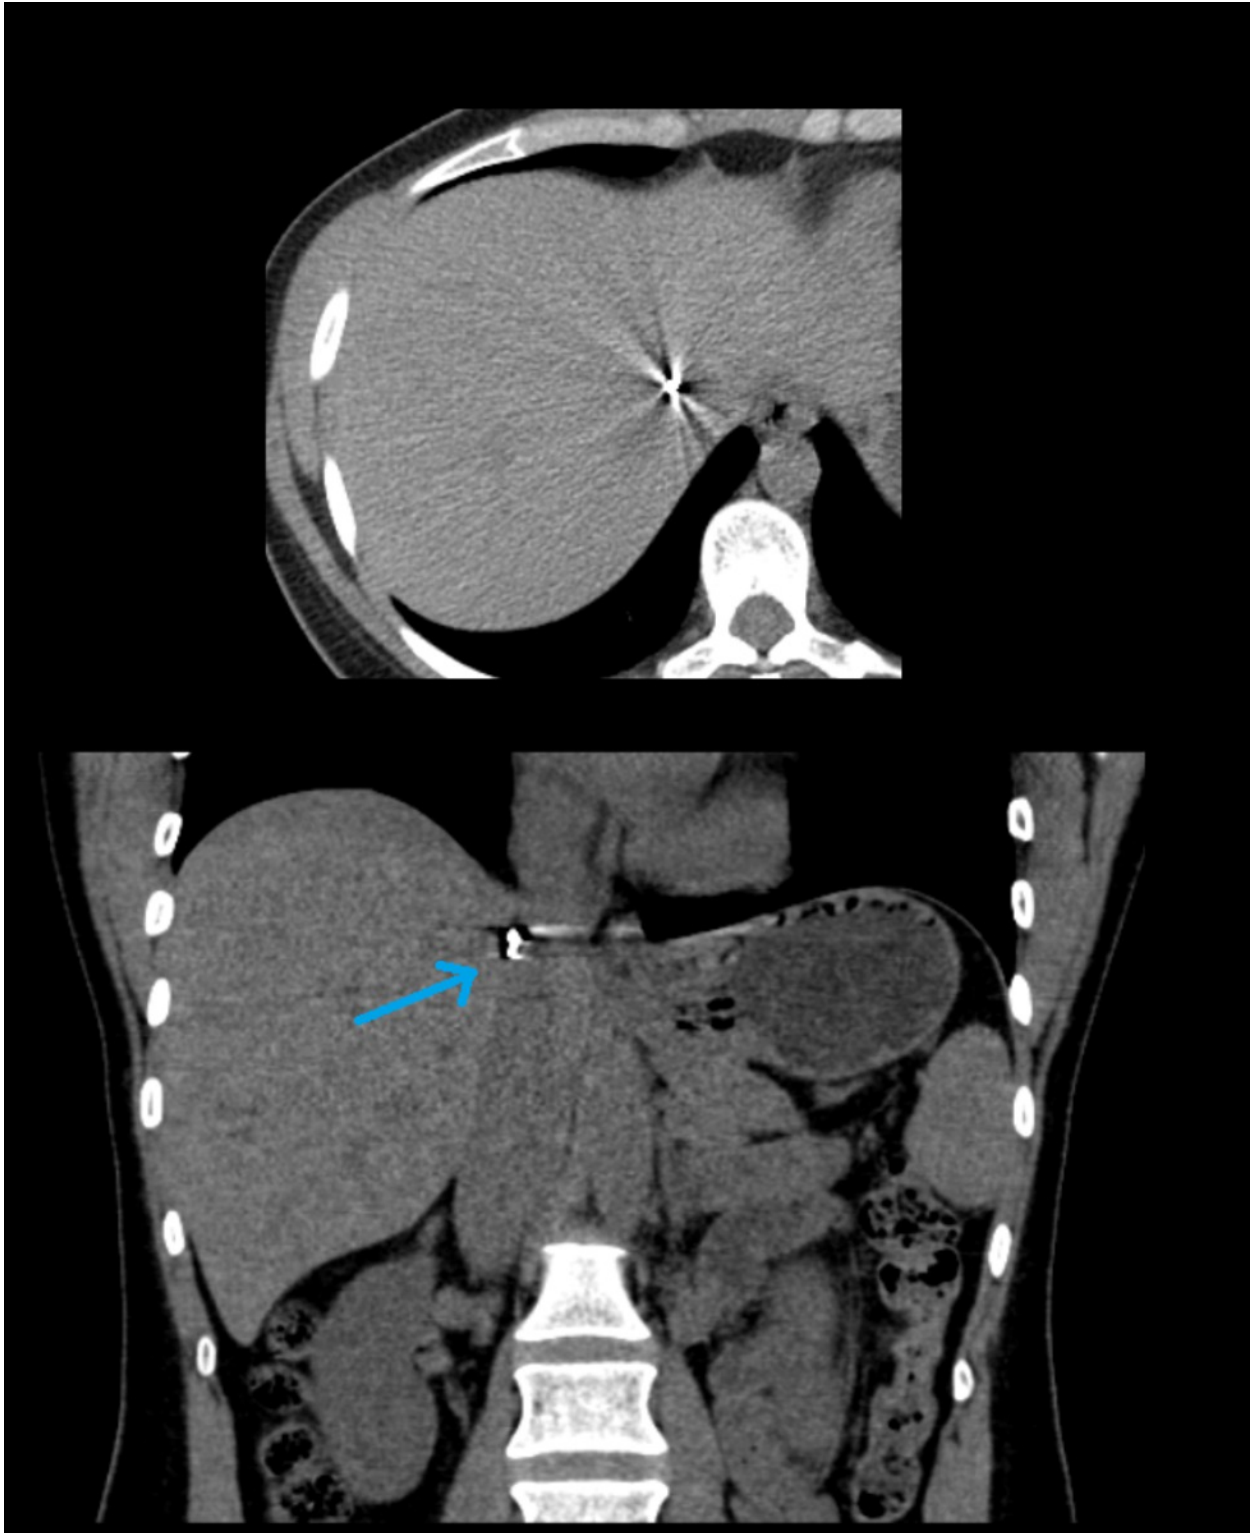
Foreign body in the intrahepatic IVC (blue arrow in unenhanced CT scans) after a gun shoot accident.
